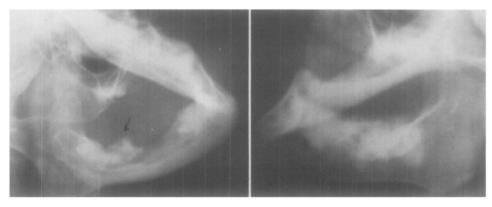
Radiographs taken in 1970, showing diffuse areas of radiopacity involving the mandible. Right side of the mandible shows an area undergoing sequestration (arrow).
